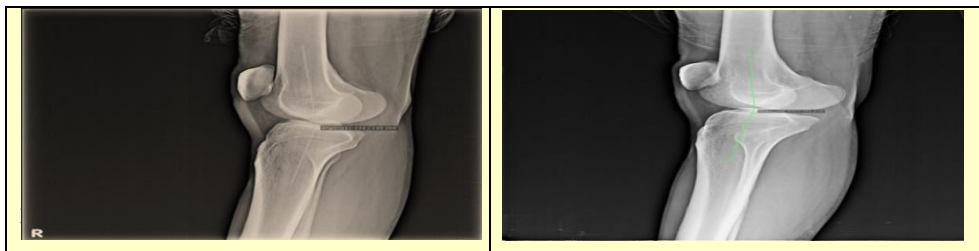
Shows Patient 1 Pre vs. Post Therapeutic X-ray of Right Knee
